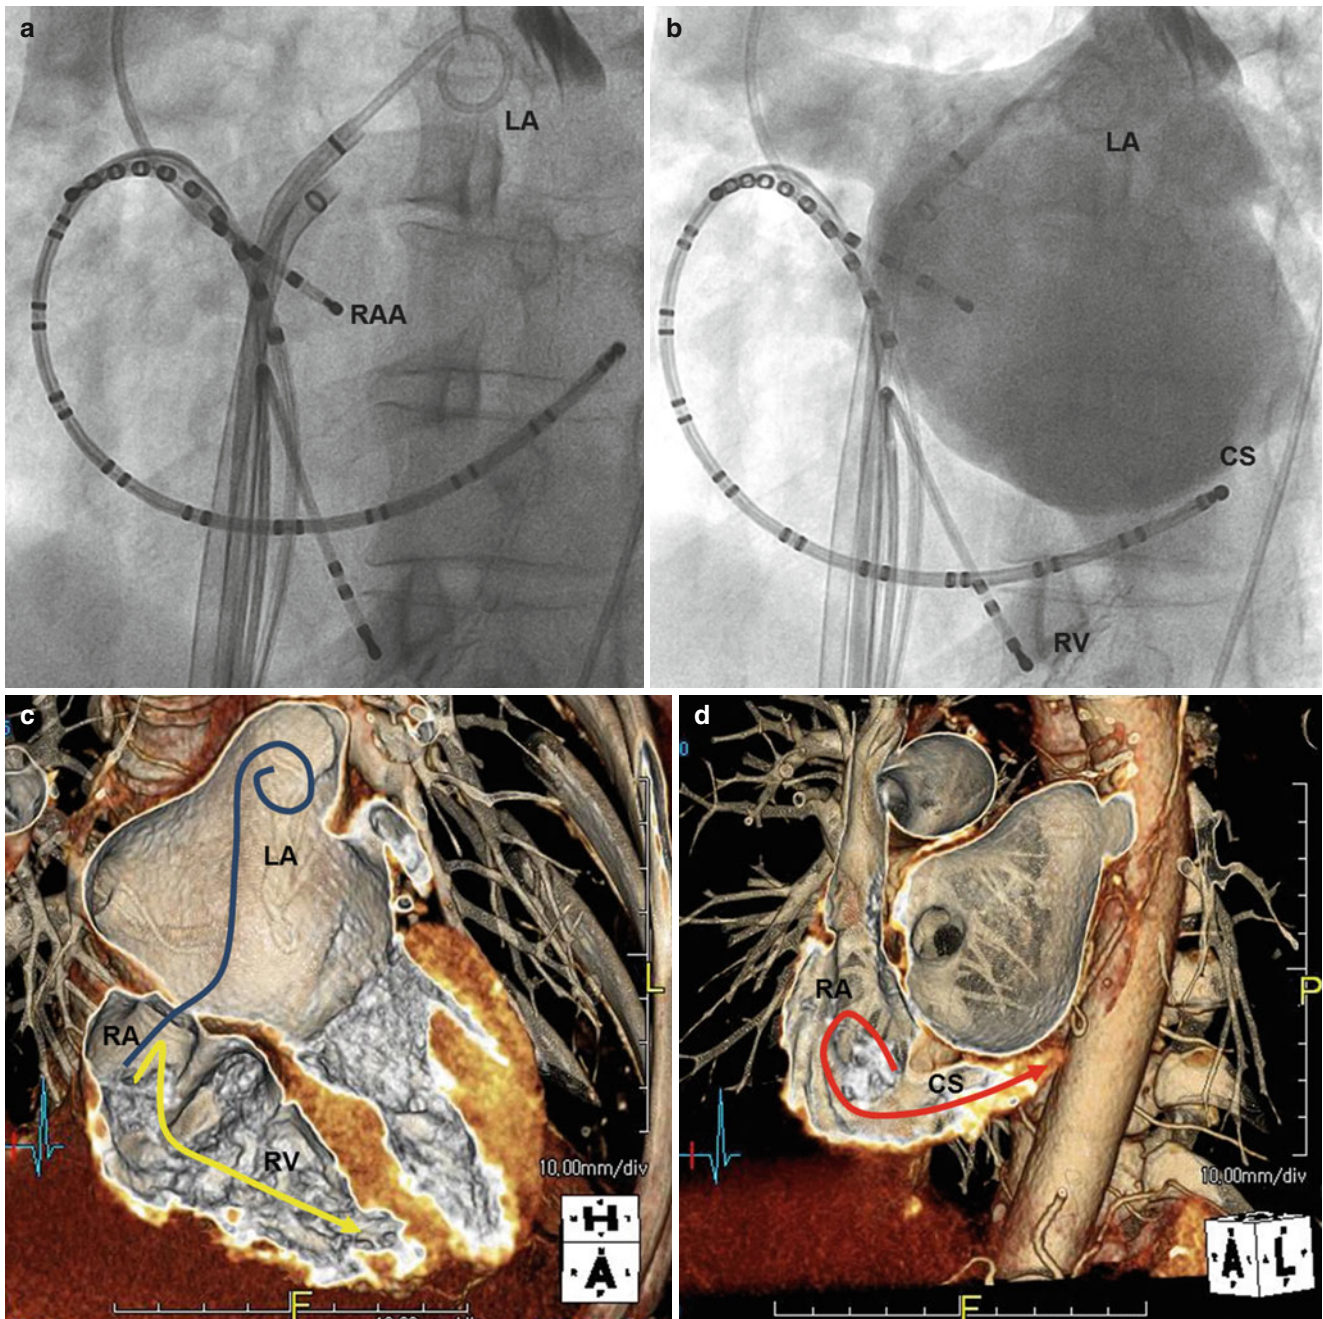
Interventional electrophysiologic approach. For the fluoroscopy, radiographies (a, b) show three intracardiac catheters, which have been introduced via the inferior vena cava into the coronary sinus, the right ventricular apex, and the right atrial appendage. Volume-rendered CT images (c, d) show the routes of intracardiac catheters into
